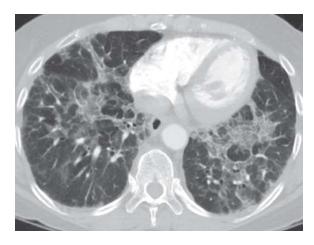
HRCT appearance of acute interstitial pneumonia²⁰
